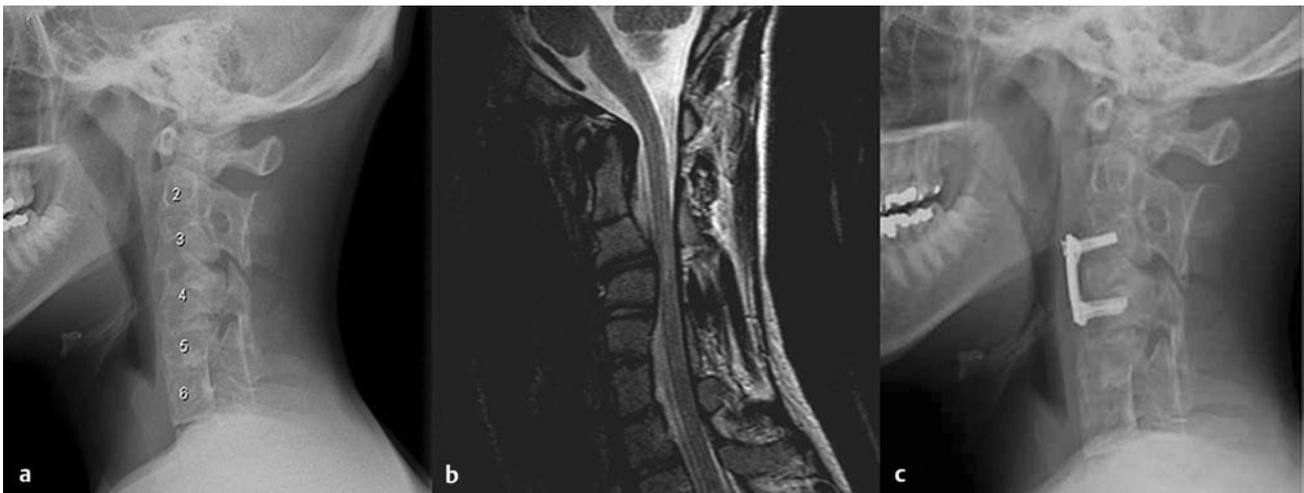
(a) Radiograph of the lateral cervical spine of a patient with Klippel-Feil syndrome demonstrating multiple fused cervical vertebrae. (b) Sagittal T2-weighted magnetic resonance image from the same patient shows spinal canal narrowing with cord compression and signal change at the C3–4 disk space. (c) Three-month postoperative lateral radiograph after an anterior cervical discectomy and fusion with plating reveals solid bony fusion.
